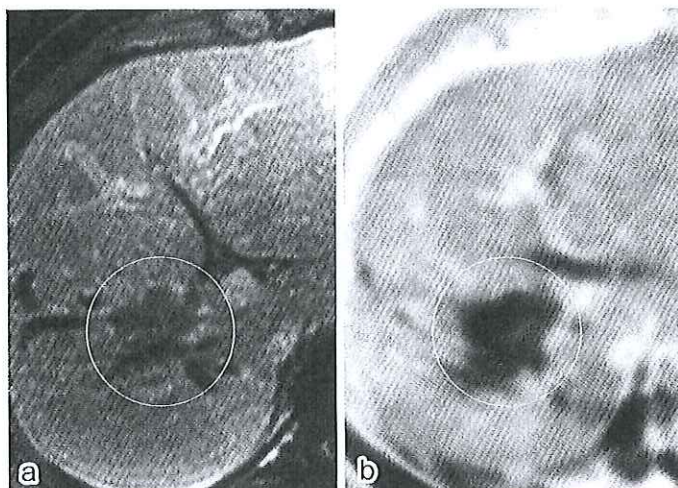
腹部造影 MRI 所見 a：門脈右枝分岐部に腫瘤所見。b：拡散強調画像（DWI）では腫瘤が高信号で描出された。
